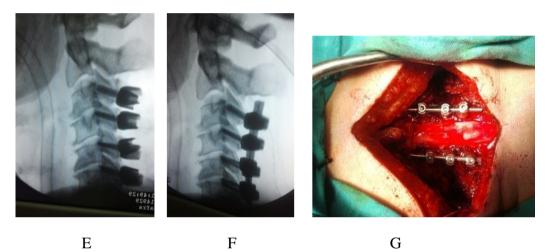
(A) Preoperative plain X-ray cervical spine lateral view of a male patient 57 years old presented with quadromyelopathy, operated with cervical laminectomy with lateral mass fixation, (B) Preoperative multislice CT cervical spine, (C, D) Sagittal MRI T2 weighted image of the cervical spine of the same patient before surgery, (E, F) fluoroscopic photo of the cervical spine after the insertion of the screws in lateral view of the same patient, (G) operative photo of the same patient after fixation.
